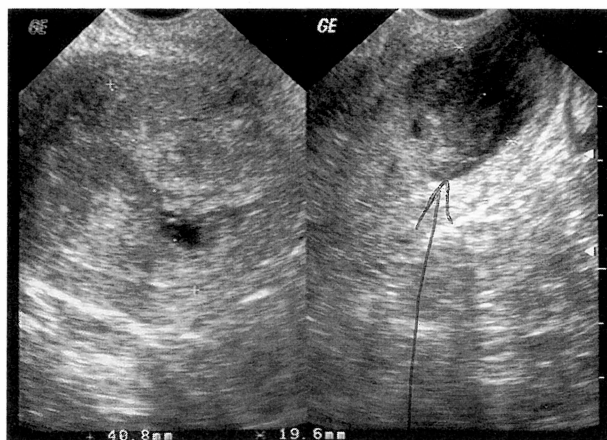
Vaginal ultrasound scans demonstrating endometrial thickness of 19.6 mm.
